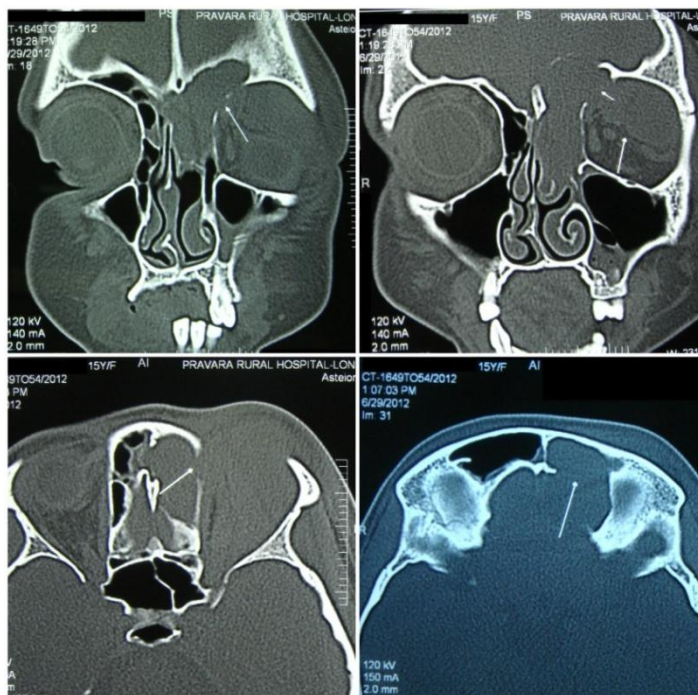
CT scan images showing homogenous isodense well defined cystic lesion eroding the lamina papyracea, posterior frontal sinus wall extending into the left retrobulbar space
